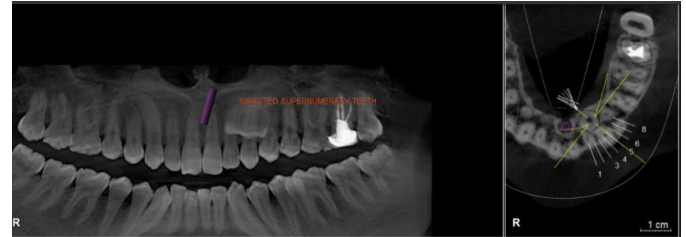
Examination of the images from the CBCT shows the palatal location of tooth.
